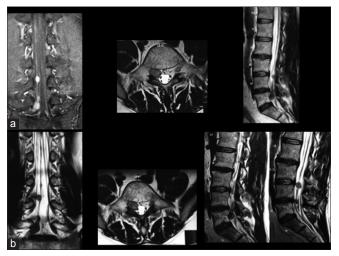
Coronal, sagittal, and axial T2-weighted contrast-enhanced magnetic resonance imaging of the spine that revealed a contrast-enhancement of two nodular formations, one in the L4 nerve root and the second distally in the right lateral recess of the spinal canal (a). After 6 months, the lumbar magnetic resonance imaging showed that a tumor of the nerve root had grown (b)
